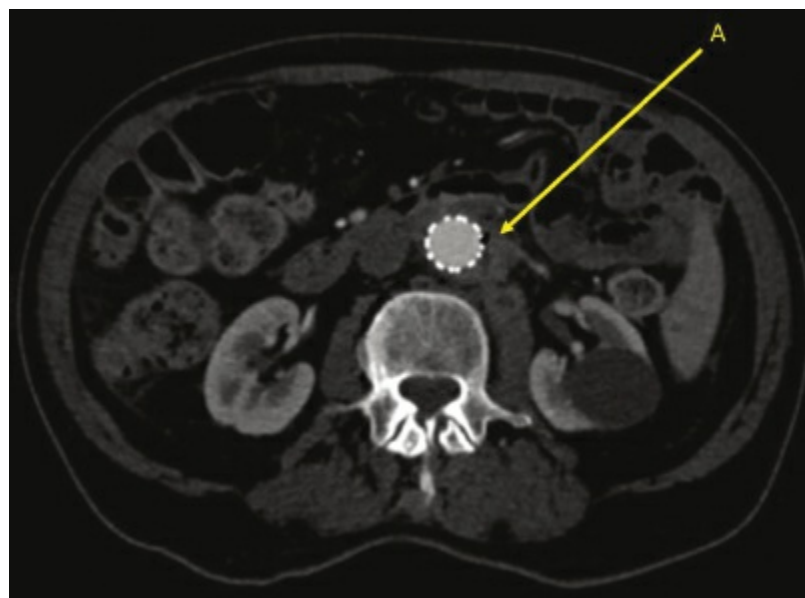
CT scan demonstrating perigraft air (A) surrounding an endograft as a sign of graft infection associated with a possible aortoenteric fistula.
